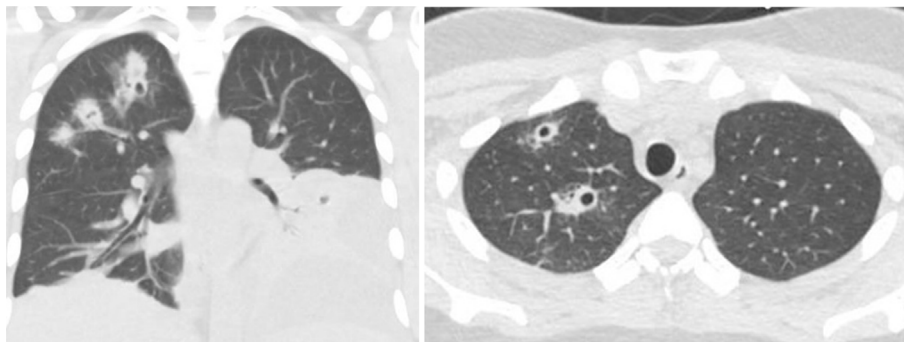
Repeat Computed tomography of the chest showing decrease in the size of the bilateral nodular opacities with the majority demonstrating new areas of cavitation but an increased moderate left pleural effusion with near complete atelectasis of the left lower lobe.
